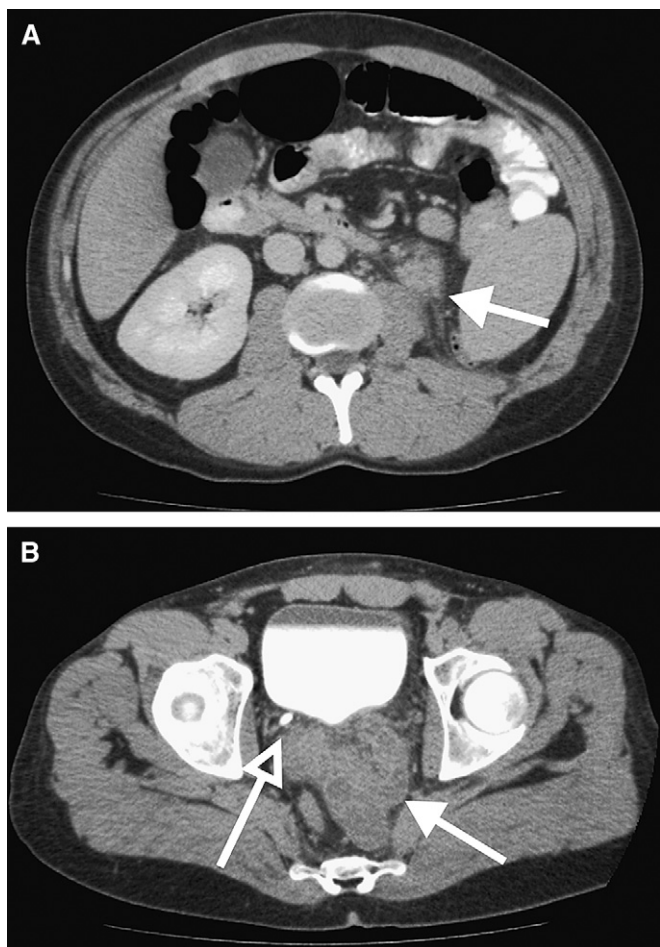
Enhanced axial computed tomographic images after oral and intravenous contrast obtained in the portal venous and delayed phases. (A) Normal right kidney and dysplastic left kidney (solid arrowhead), with associated retroperitoneal stranding are visualized. (B) Delayed phase shows the right ureter draining into a contrast-filled bladder (open arrowhead); large, distended seminal vesicle cysts are present posterior to the bladder (closed arrowhead).
